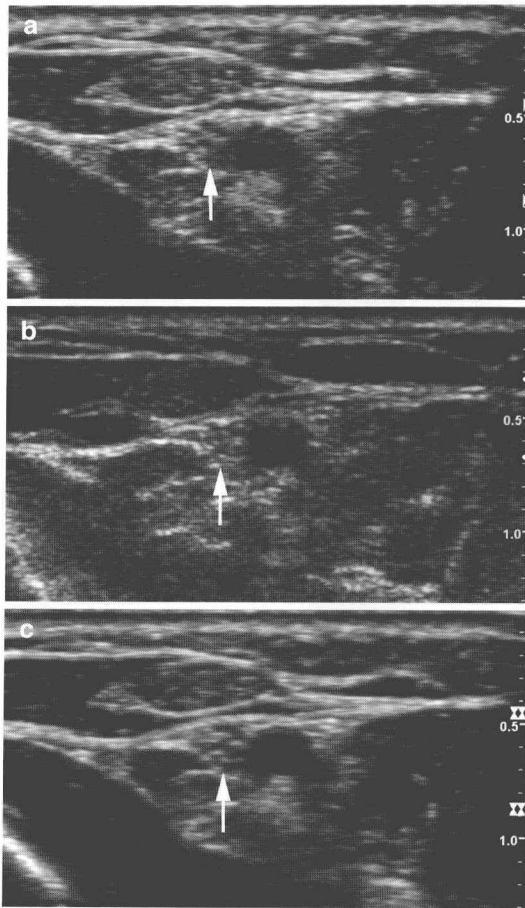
Transverse ultrasound images through median nerve (*arrow*) in a healthy volunteer taken with a 15 MHz transducer on a GE Logiq9 with (a) and without (b) tissue harmonic imaging. In contrast to the effect of compounding (Fig. 1.5), there is only minimal change in the image quality by the use of harmonic imaging. The addition of image compounding to the harmonic image (c) results in the best image quality in this series of images
